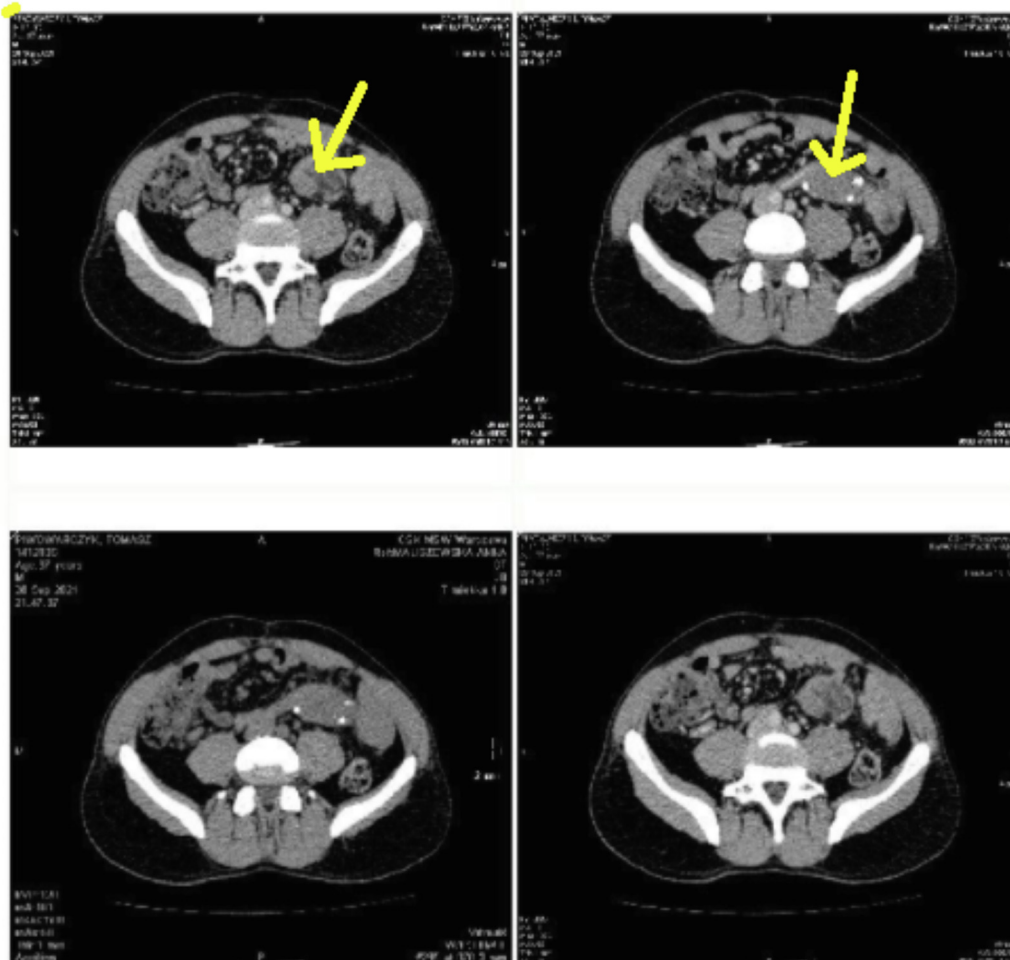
Case 17. Abdominal computed tomography scan. The abdominal computed tomography scan revealed that the transplanted pancreas was enlarged, was heterogeneous, had edema, had arterial vascularization of the graft from the right iliac artery only in the initial segment, and had venous outflow only slightly visible in the proximal part. The yellow arrow shows a transplanted pancreas.
